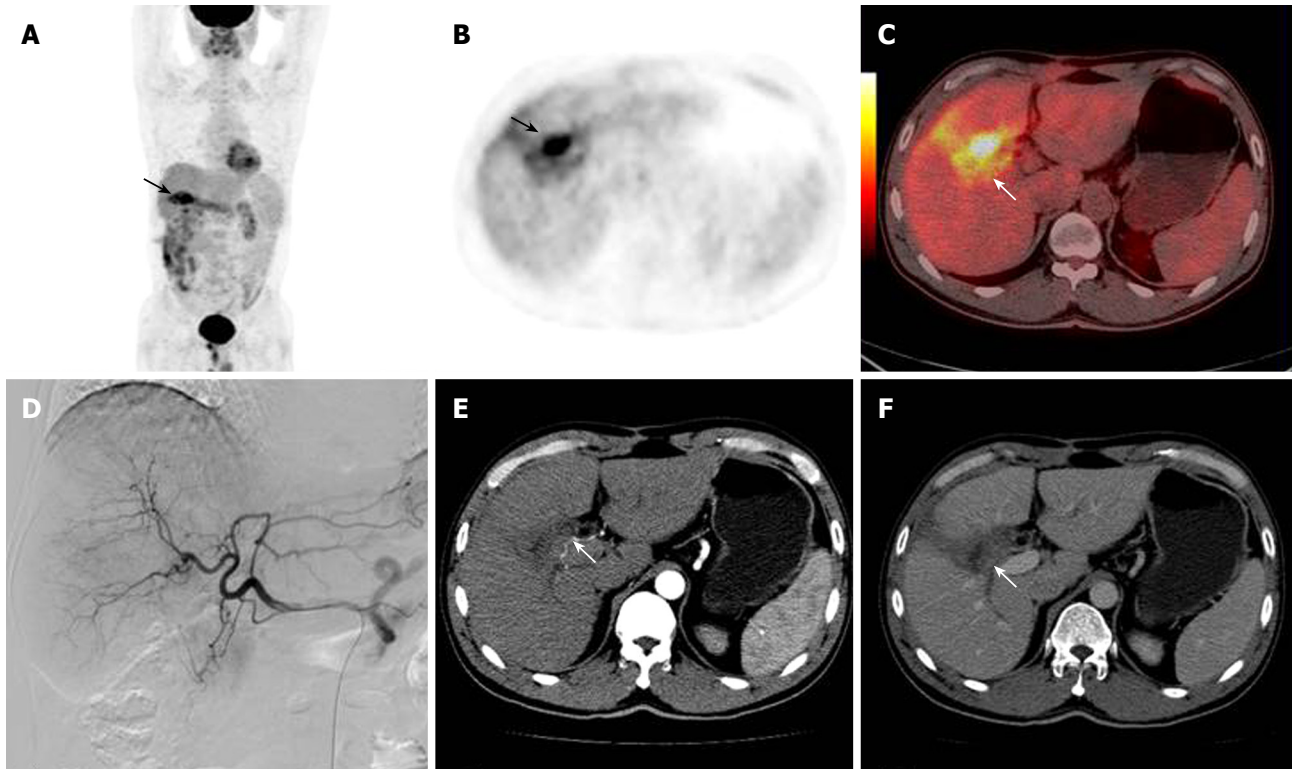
A 48-year man who had HCC resection 2 mo before the imaging, followed by TACE 40 d later. PET and PET/CT fused images revealed highly metabolic lesions (arrows, A-C). Both contrast-enhanced axial CT imaging and arteriography failed to show lesions in the right lobe of the liver (arrows, D-F). These findings of PET/CT were later verified as inflammatory by post-operative tissue examination.
